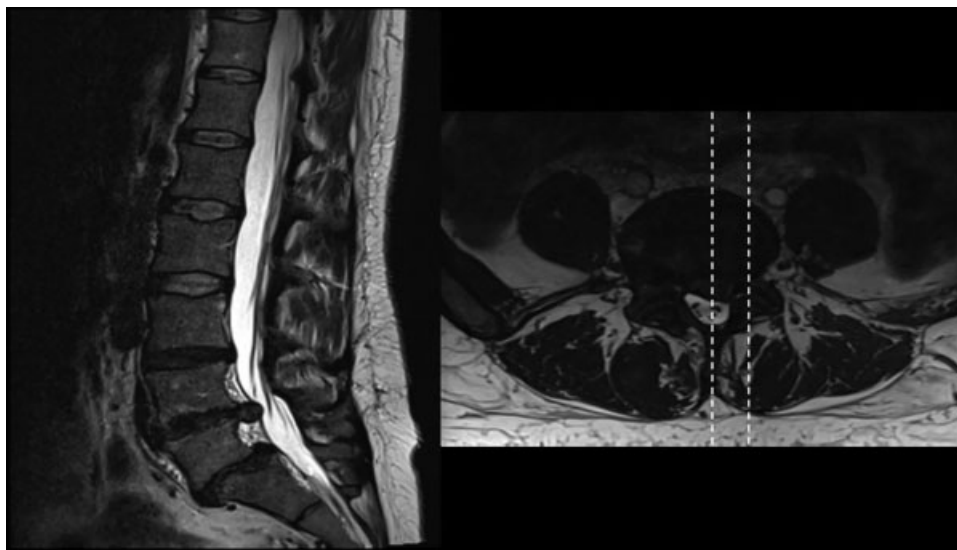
The sagittal and axial slices of the T2-weighted constructive interference in steady state (CISS) sequences. With help of the CISS sequence, the individual midline was identified in each data set.
